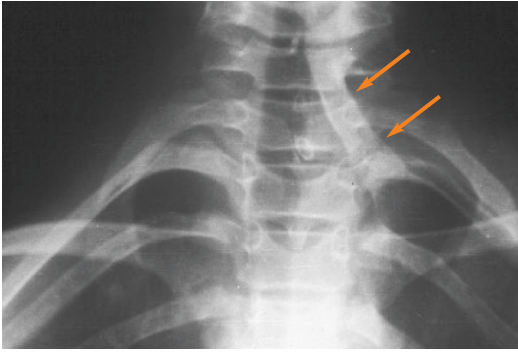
X-rays of an omovertebral bone (arrows)
